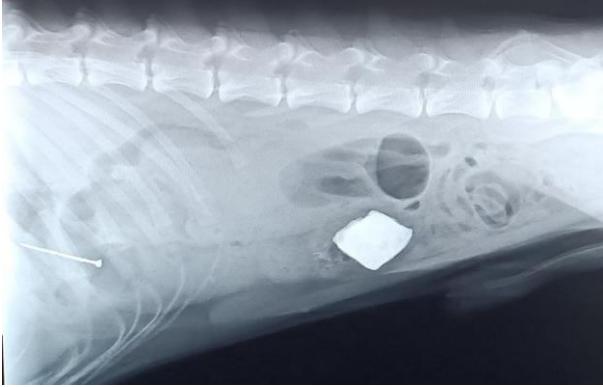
Lateral view radiograph showing foreign bodies
